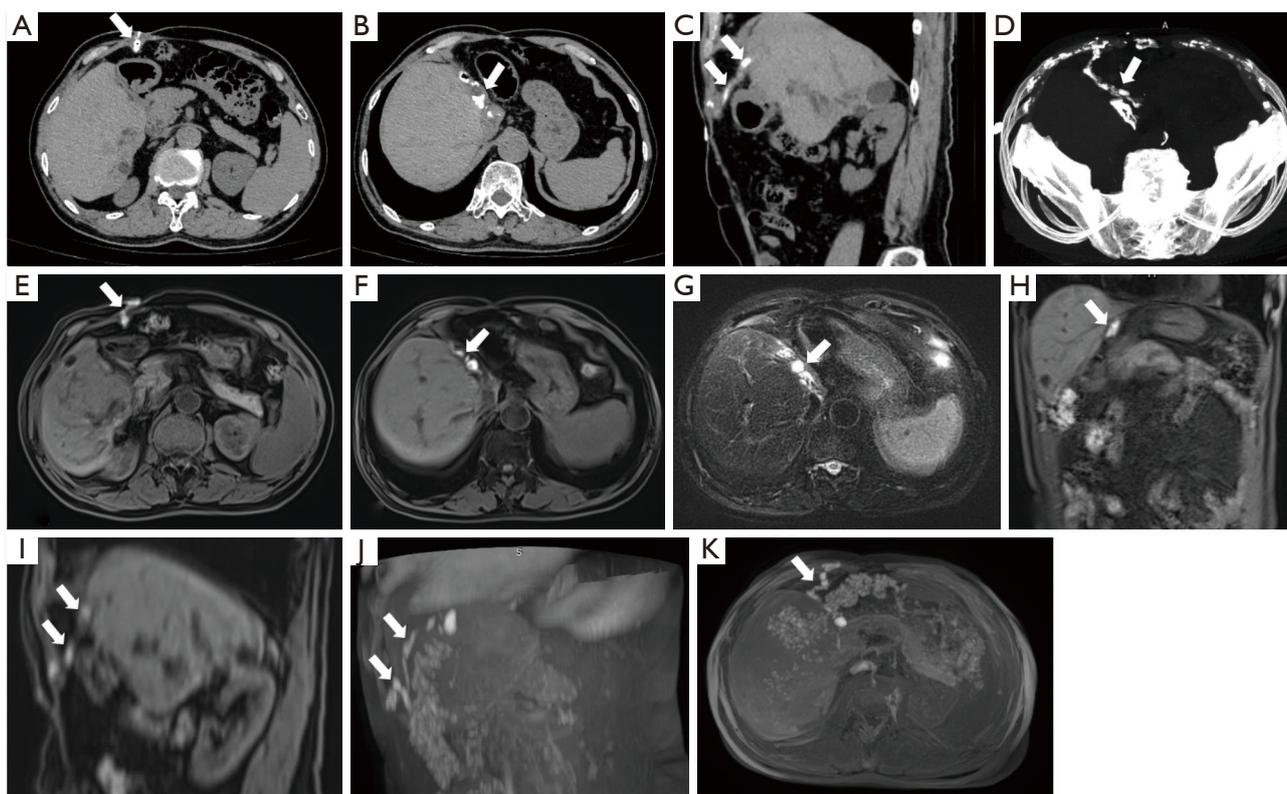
A 66-year-old man diagnosed with abdominal chronic wounds 2 years after partial hepatectomy. (A-D) CT images of sinography/fistulography, MPR and MIP; (E-H) MR sinography/fistulography images of axial fat-saturated T1w, axial fat-saturated T2w and coronal fat-saturated T1w sequences; (I-K) MR images of MPR and MIP. The chronic wounds (white arrows) demonstrated as a contrast agent filled tortuous sinus tract with small bubbles, involving abdominal cavity and extending to liver. CT, computed tomography; MR, magnetic resonance; MIP, maximum intensity projection; MPR, multiplanar reconstruction.
